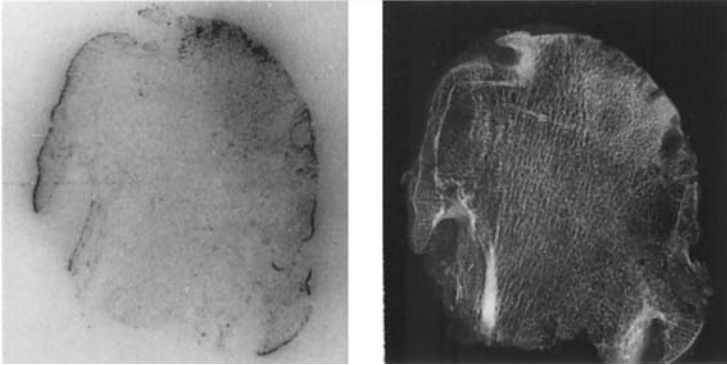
Autoradiogram from arthrotic femoral head given ^{99m}Tc-polyphosphate preoperatively (left). The radionuclide is predominantly accumulated at the cyst wall of the weight-bearing area and at the osteochondral junction in the osteophytes. Corresponding radiograph of a thin slice of femoral head (right).
